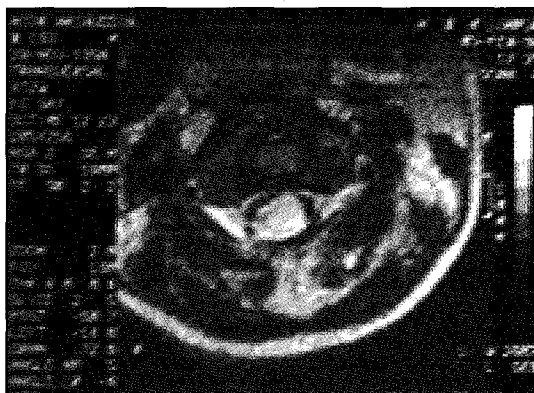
MRI films showing a unilateral oedema of the spinal cord at the level of C1 to C2.
